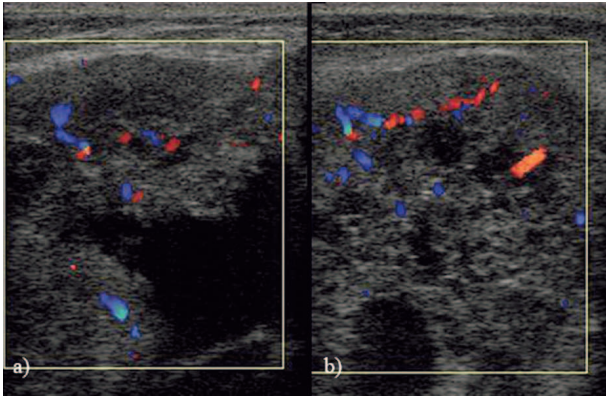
The Doppler ultrasound reveals a hypervascular tumor.
